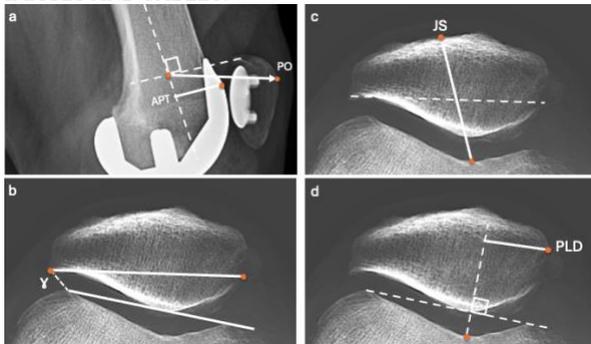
Radiographic measurements of patellar position
